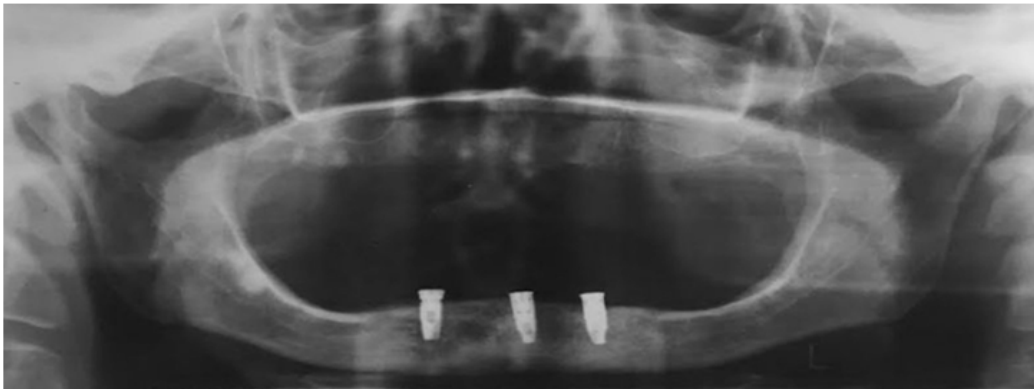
Panoramic radiograph taken after implant installations
